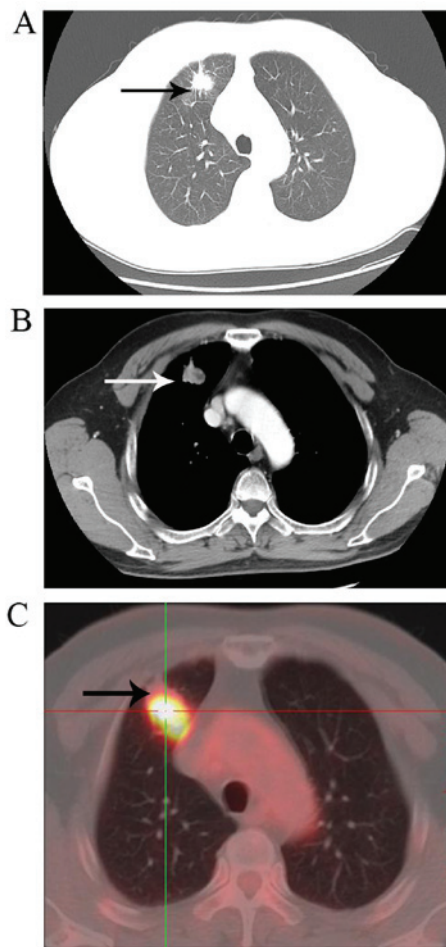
Radiological presentation. (A) Chest computed tomography viewed on the lung window (axial and coronal) indicated a 3.0x1.1x2.0 cm irregular mass (arrow) with rough edges, which is called 'spiculation sign' in the upper lobe of the right lung. Pleural pull signs were visible around the mass. (B) Mediastinal window of chest enhanced computed tomography scan indicated the inhomogenous density of the mass (arrow). (C) Positron emission tomography-computer tomography scanning of the chest indicated a strong accumulation of fluorin-18 fluorodeoxyglucose (arrow) in the upper lobe of the right lung and the maximum standardized uptake value (SUV) was 14.1.
